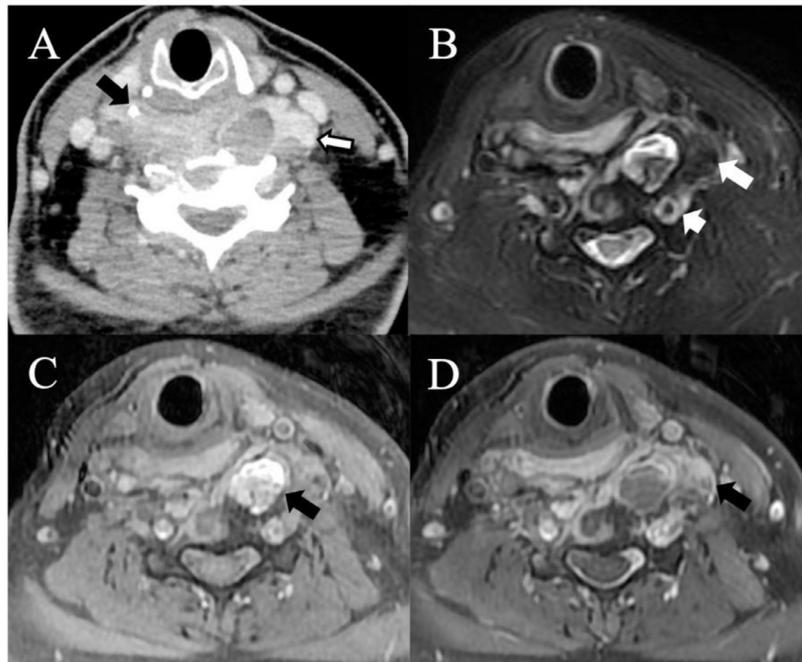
(A) Axial contrast-enhanced CT image; (B) Axial fat-suppressed T2W image; (C) Axial fat-suppressed T1W; and (D) Axial fat-suppressed T1W image post-gadolinium after 6 months of adjuvant chemotherapy of synovial sarcoma in the retropharyngeal space in a 32-year-old male patient. The lesion was significantly reduced, with new calcification (A, black arrow) and focal bleeding appearing at the liquid-liquid level (C, black arrow). The white arrow and short white arrow in B showed iso- and high-signal tumor parenchyma with a low bleeding signal, making a “triple sign.”
